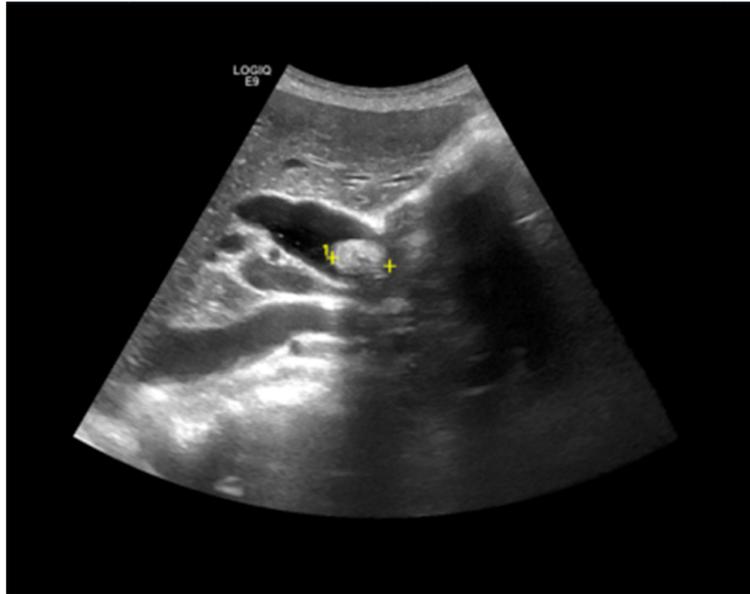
Standard ultrasound – obstructive jaundice. Large common bile duct stone of about 19 mm, common bile duct much dilated upstream (right).
